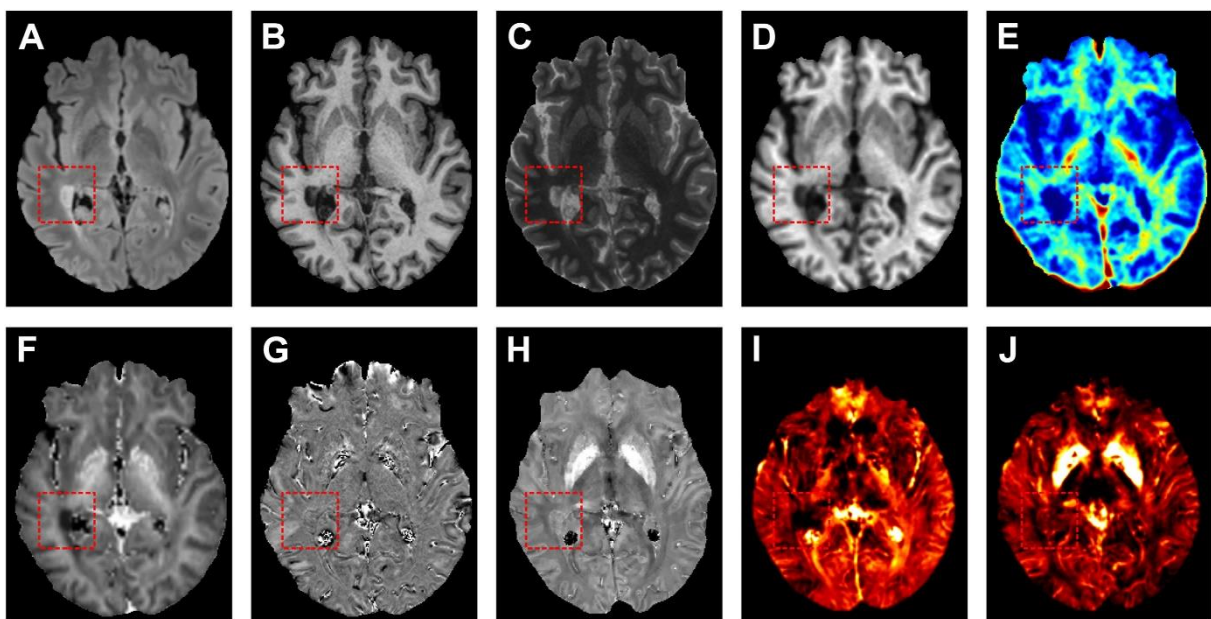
Examples of advanced MR images from a patient with MS, with a right periventricular lesion highlighted by a red-dotted square. (A) Conventional FLAIR, (B) MP2RAGE, (C) qT1, (D) MTsat, (E) MWF, (F) neurite density index from multi-shell diffusion, (G) unwrapped phase, (H) QSM, (I) χ -separation diamagnetic component, (J) χ -separation paramagnetic component. From Cagol et al., *Neuroimaging Clin N Am*, 2024
